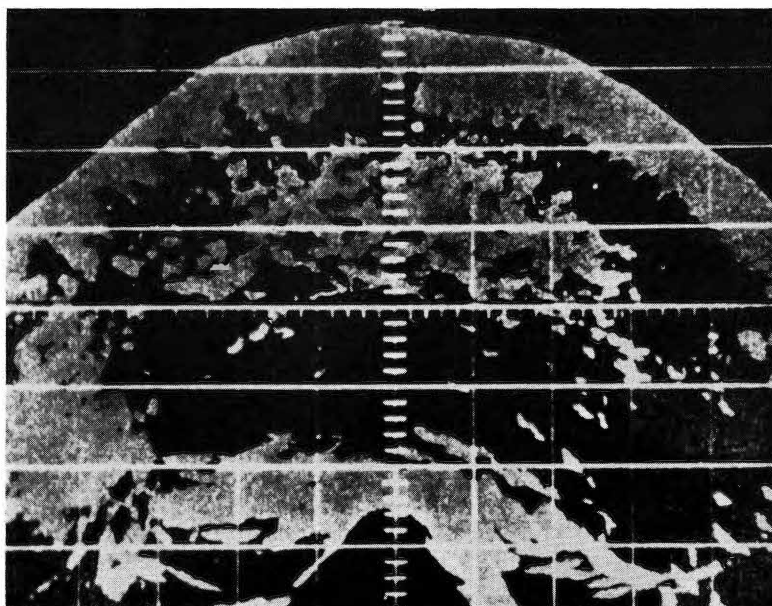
Sonogram in a patient at 16 weeks of gestation who had a proven hydatidiform mole. This characteristic echo pattern is quite different from that seen in previous pictures of the well-organized outline of fetal parts. Reprinted from *Am. J. Obstet. Gynec.* 90: 655, 1964. (C. V. Mosby)
